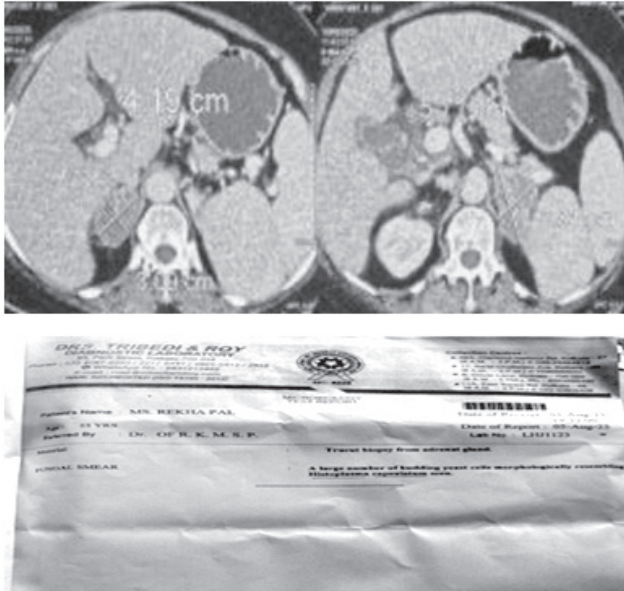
Contrast-enhanced CT abdomen showing bilaterally enlarged adrenal glands.
